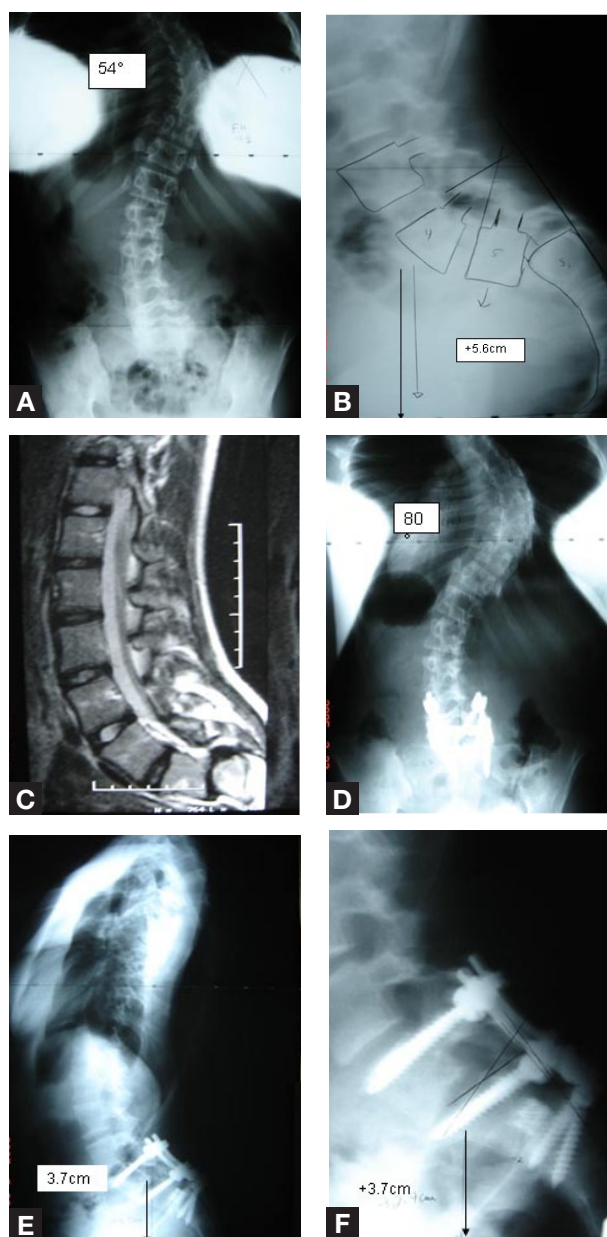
(A,B) Preoperative anteroposterior (AP) and lateral plain films show high-grade spondylolisthesis associated with scoliosis with significant sagittal imbalance. (C) Preoperative magnetic resonance image. (D) Postoperative AP film shows lack of correction of scoliosis, which was treated later with combined thoracoscopic anterior release and fusion and posterior instrumented fusion. (E,F) Lateral films show improved sagittal balance.
